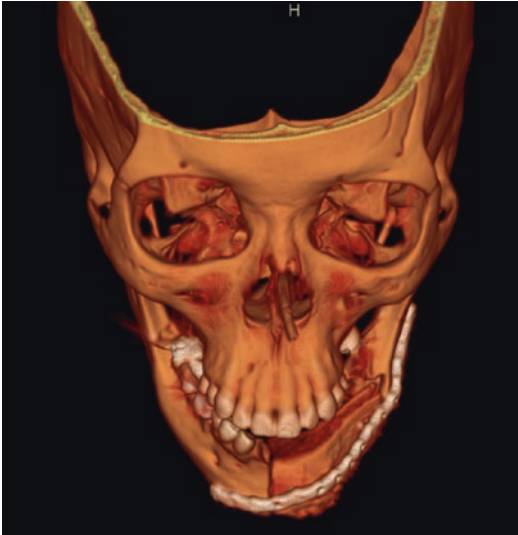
3D CT of DCIA reconstruction of mandible
